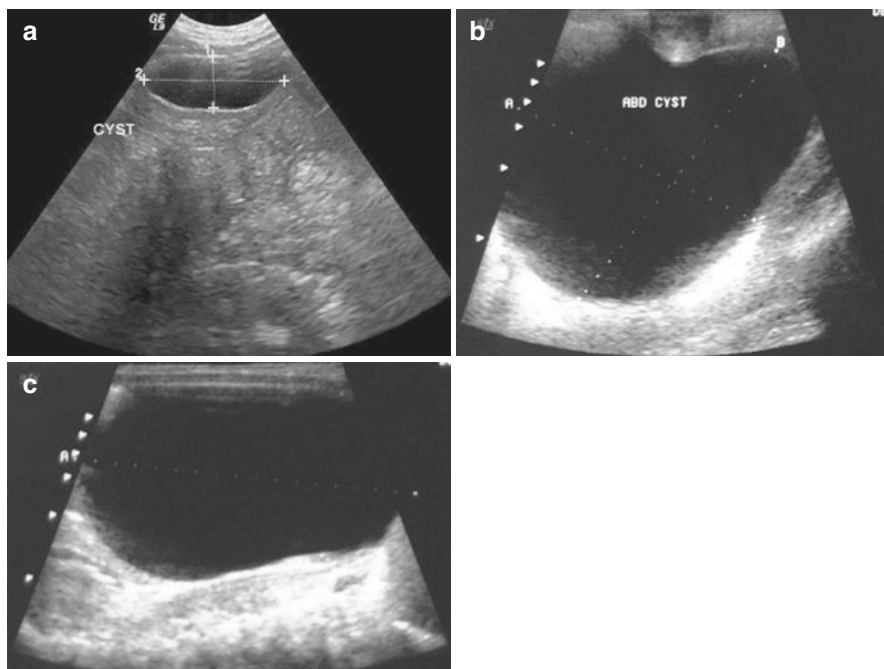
(a–c) Abdominal and pelvic ultrasounds showing a small ovarian cyst in the upper one and a large ovarian cyst in the lower one
